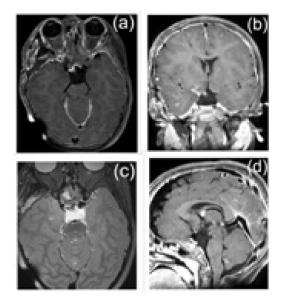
(a) (b) TIWI MRI brain shows near total excision of Craniopharyngioma.
